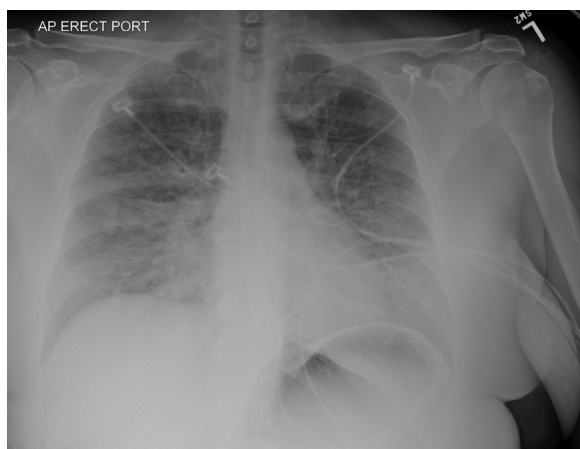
Chest radiograph revealing acute pulmonary edema.
